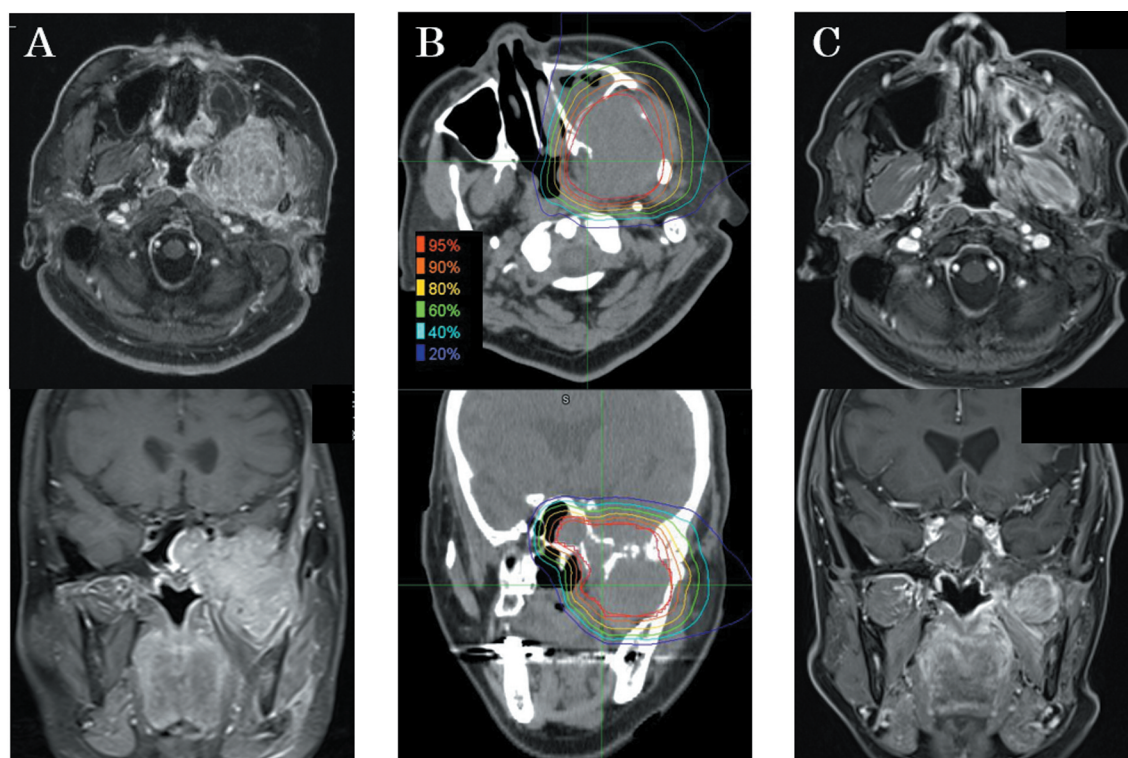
Representative case of undifferentiated pleomorphic sarcoma of the pterygopalatine fossa treated with carbon-ion radiotherapy (C-ion RT). A 60-year-old female patient had tumor invasion of the pterygopalatine fossa. A: Contrast-enhanced T1-weighted magnetic resonance imaging revealed the area around the pterygopalatine fossa. The patient was diagnosed with inoperable bone and soft-tissue sarcomas of the head and neck and treated with C-ion RT. B: Dose distribution of C-ion RT using 70.4 Gy (relative biological effectiveness) in 16 fractions. The gross tumor volume is shown in red. C: Twenty-four months after treatment, magnetic resonance imaging showed the tumor had shrunk. The patient has grade 2 trismus and is still alive more than 3 years after treatment. The patient additionally underwent surgery for recurrence of the lymph node at the neck 28 months later.
